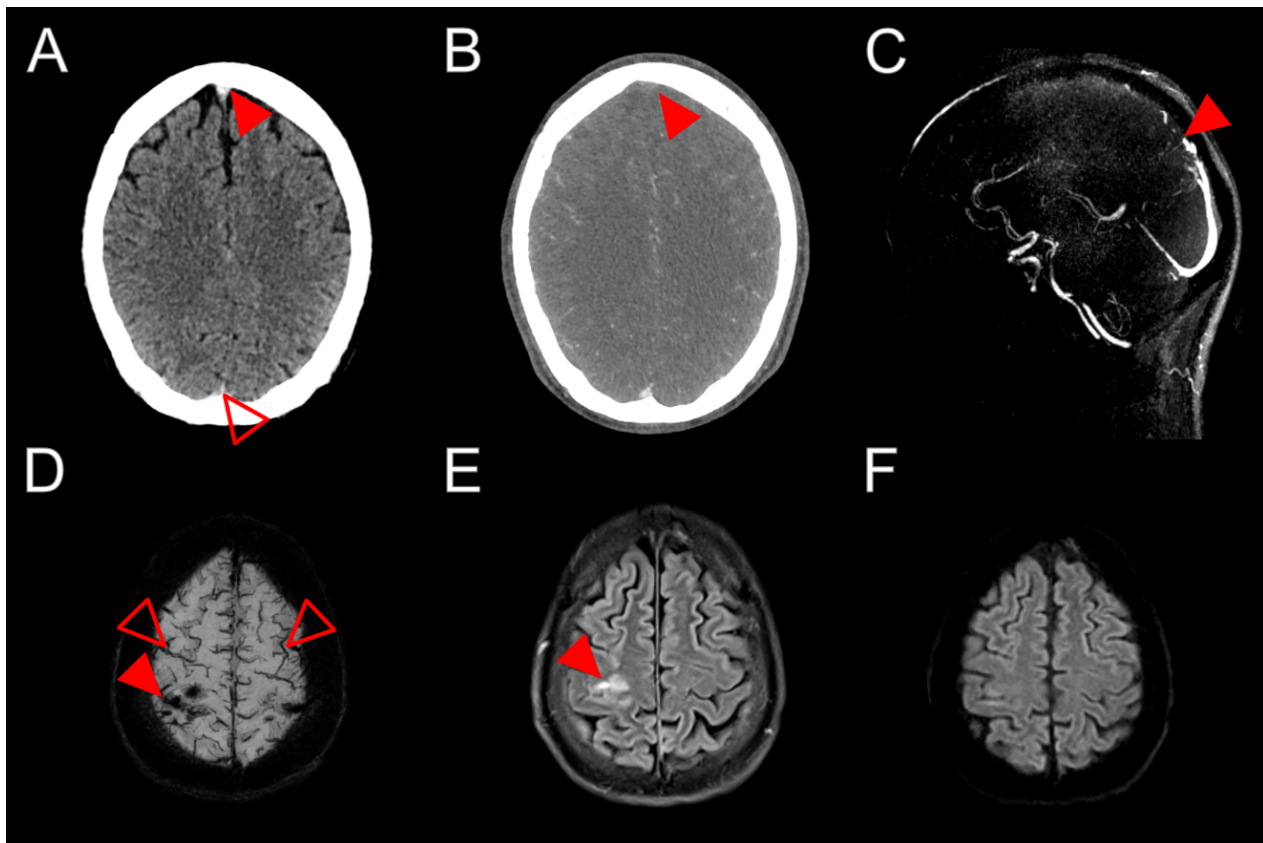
Acute CT, MRV and MRI imaging of patient in Case 3. The anterior superior sagittal sinus was denser on CT anteriorly (A, red arrow) than posteriorly (open arrow) due to acute thrombus. This was confirmed on CT and MR venography, where there was no contrast seen (B, red arrow) or flow-related signal (C, red arrow) within the anterior superior sagittal sinus. Susceptibility weighted imaging showed blooming artefact within cortical veins (red arrow) due to thrombus (red arrow) and venous congestion (open arrows) (D). The right-sided cortical vein thrombus was associated with Fluid Attenuated Inversion Recovery (FLAIR) hyperintensity within the precentral gyrus due to oedema (E, red arrow). Diffusion weighted imaging showed only subtle hyperintensity but no evidence of venous infarction (F).
